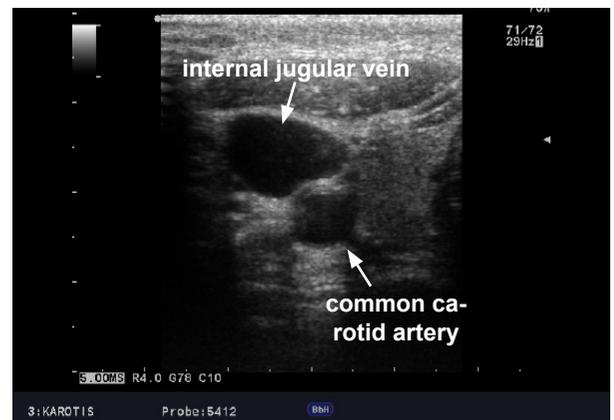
Ultrasound of right cervical vessels: lateral the internal jugular vein, medial the common carotid artery (The vein can be compressed easily, but not the artery.)
